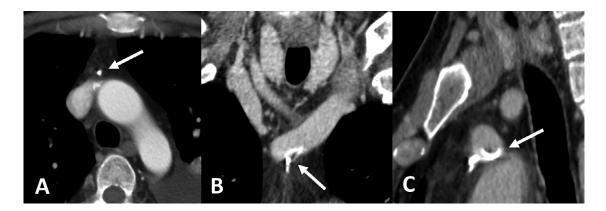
Post embolization contrast-enhanced CT images of the axial A: and oblique coronal B: and sagittal view C. Post embolization contrast-enhanced CT shows NBCA-Lipiodol accumulation (arrow) along the inside of the left brachiocephalic venous wall.
